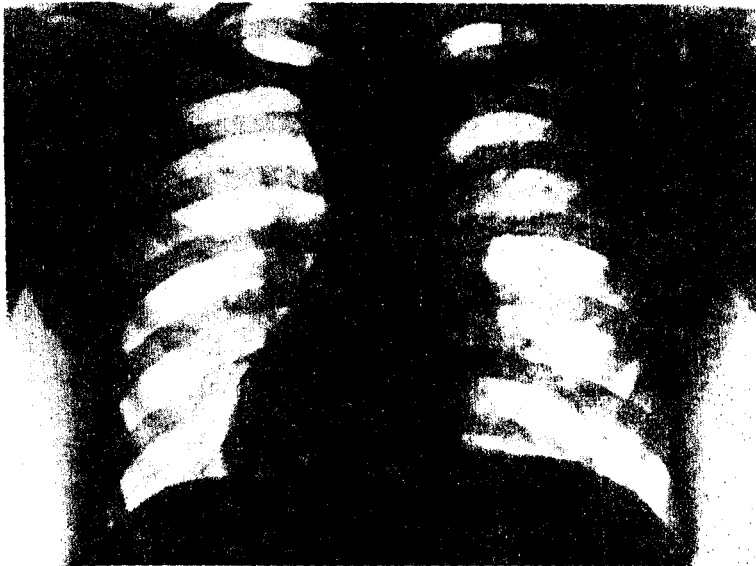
Roentgenogram of the chest on admission to hospital.
